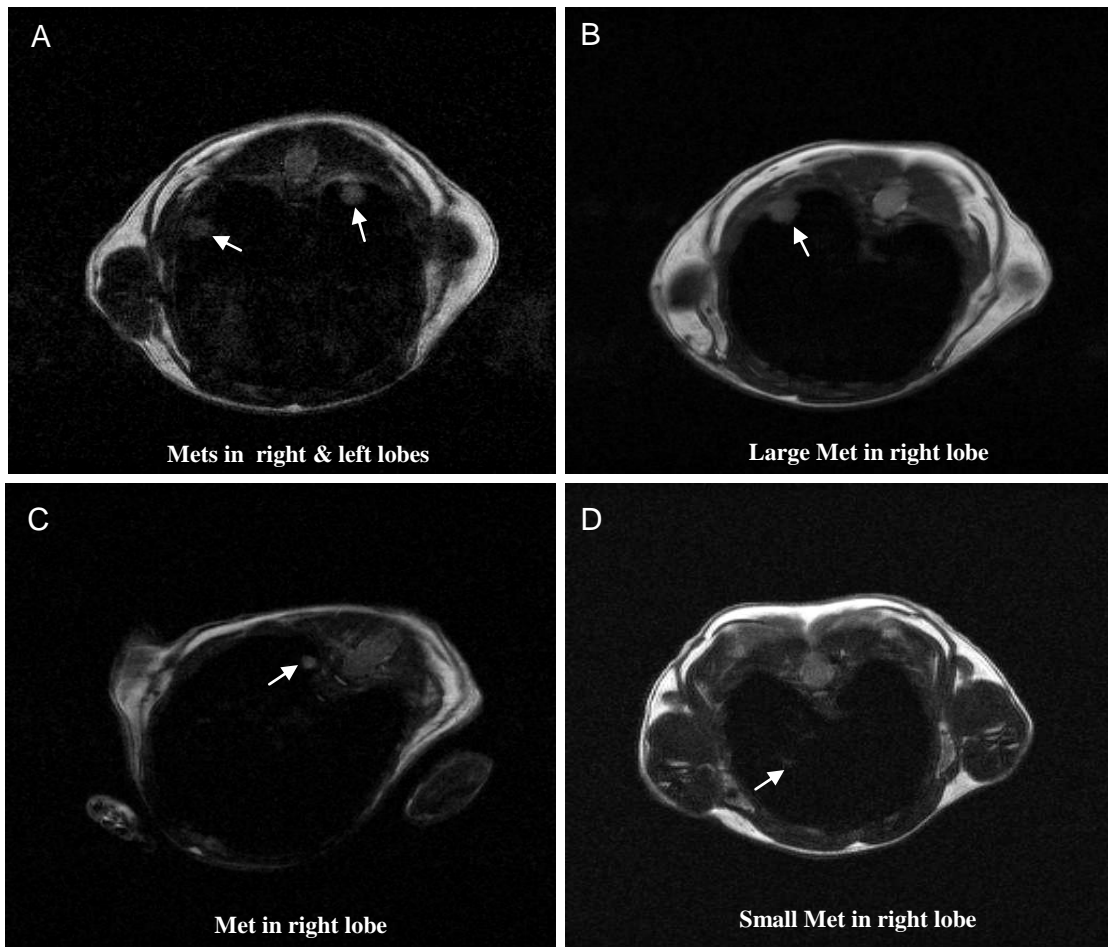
Transverse views of thoracic cavity showing detection of lung metastases using MRI
